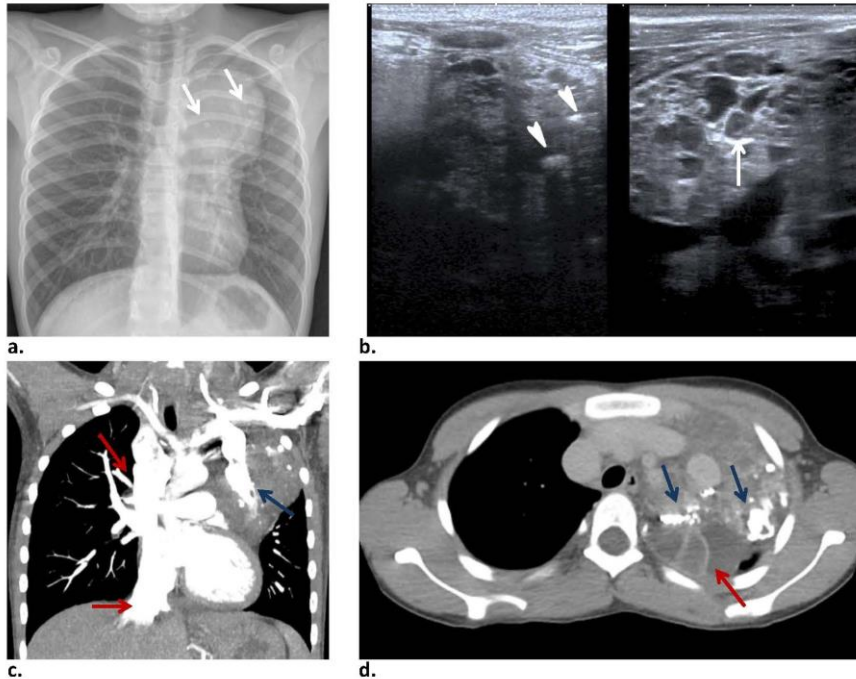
(a) PA thoracic radiography shows an anterior mediastinal mass with calcifications (arrows). (b) US shows venous lakes , some of them with inner content (arrow) and phleboliths (arrowheads). (c) Coronal CT angiogram reveals vascular structures that come together in a large common trunk (blue arrow) which drains into the left brachiocephalic trunk whose caliber is enlarged, the same as superior and inferior vena cava (red arrows). (d) Axial CT in delayed venous phase shows retained contrast within the cavities (blue arrows) and cystic component (red arrow).
